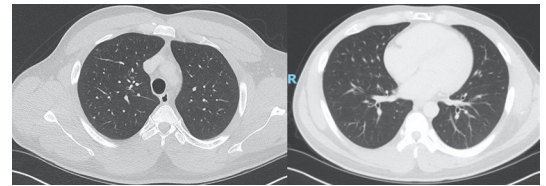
CT scan 6 months after initial presentation. Interval resolution of previously seen lymphadenopathy, and significant interval decreases in bilateral lung nodules.
